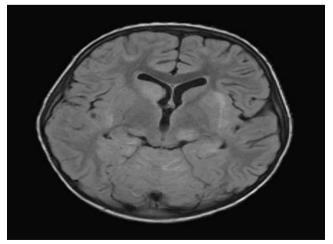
Axial MRI of the patient reported herein
